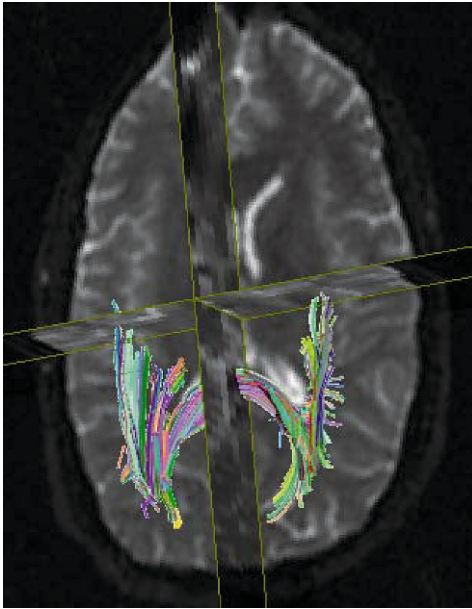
Tracking of white matter fibers on MRI
